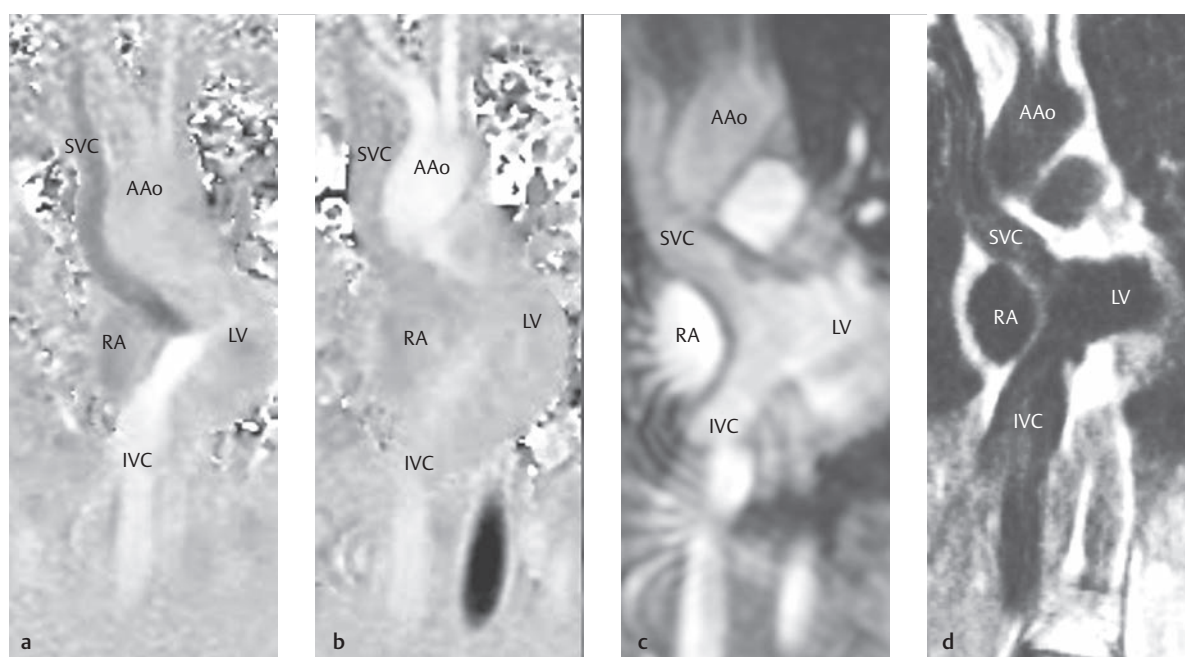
Atrial switch operation for TGA IVS. Angulated coronal depiction of the atrial tunnel in a female patient with TGA IVS after an atrial switch operation, with various MRI sequences. Regular flow in the superior and inferior vena cava (a, b) with no evidence of a baffle stenosis (c, d).
